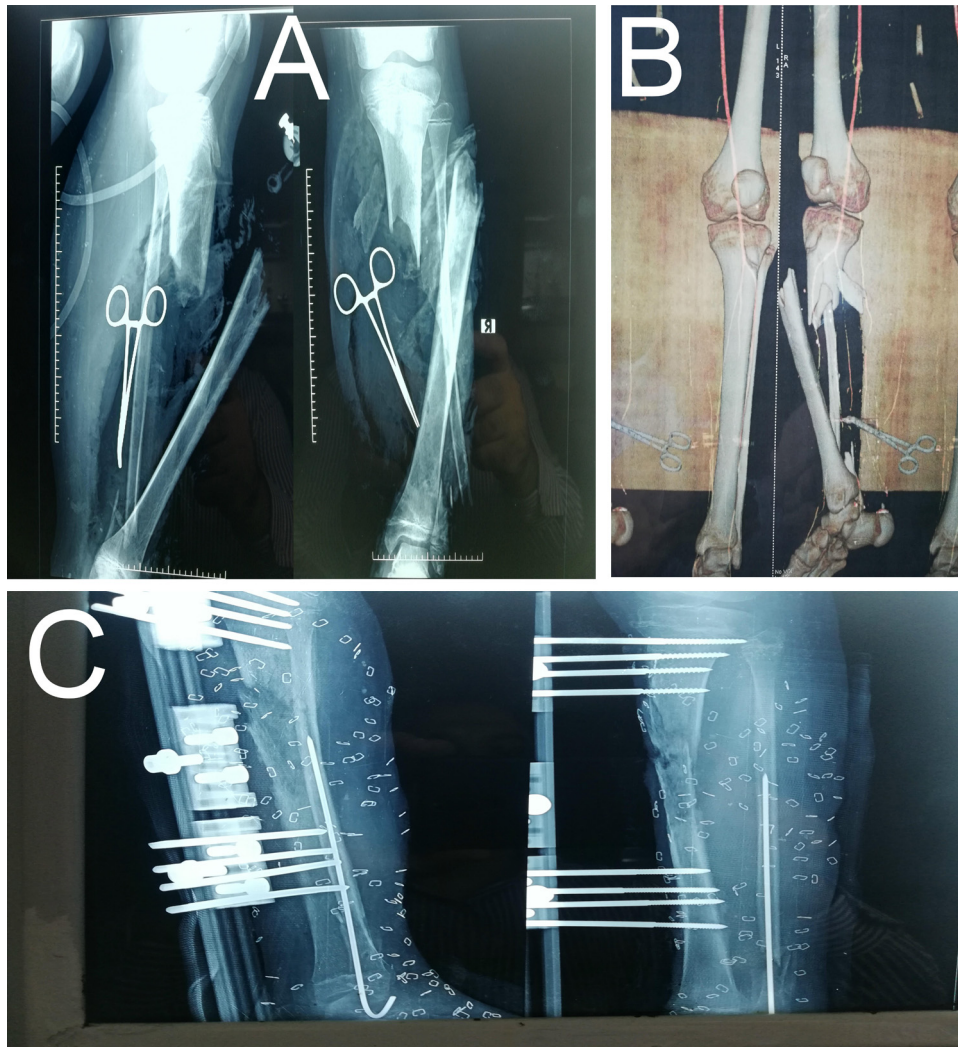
A. Plane X-rays Antero-posterior and lateral views at the time of the initial trauma show severely displaced proximal metaphysis-diaphyseal fracture of the tibia, with fracture at the distal fibula. B. C.T. Angiography shows the fracture and associated vascular injury that had been holding with arterial clamp. C. X-rays Antero-posterior and lateral views show the fracture fixation with monoplane external fixator with metallic shadows of staples for a skin graft.
